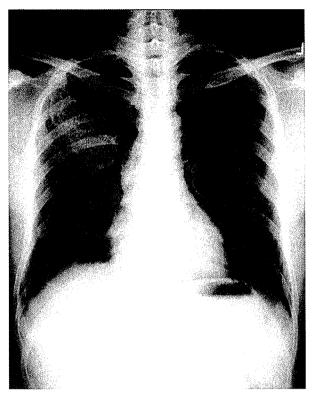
Radiography of the right second rib. The tumor is expansile with a lacy appearance.
